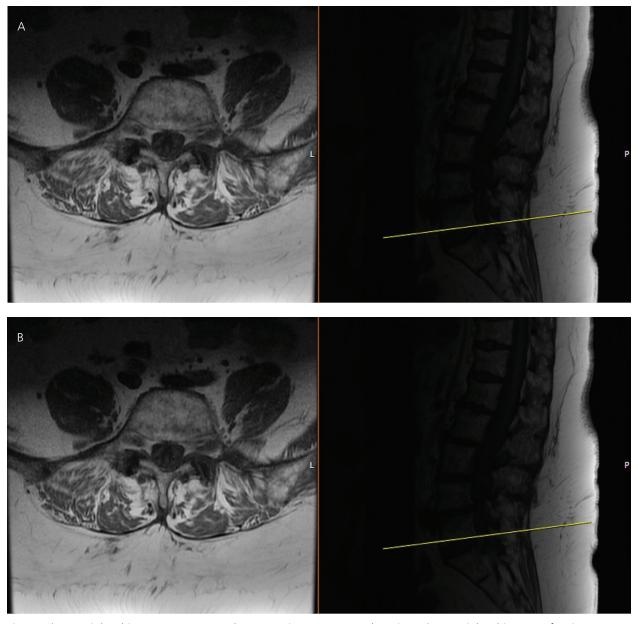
A) T1-weighted images precontrast demonstrating nerve root clumping. B) T1-weighted images after intravenous contrast administration demonstrating subtle leptomeningeal enhancement.
